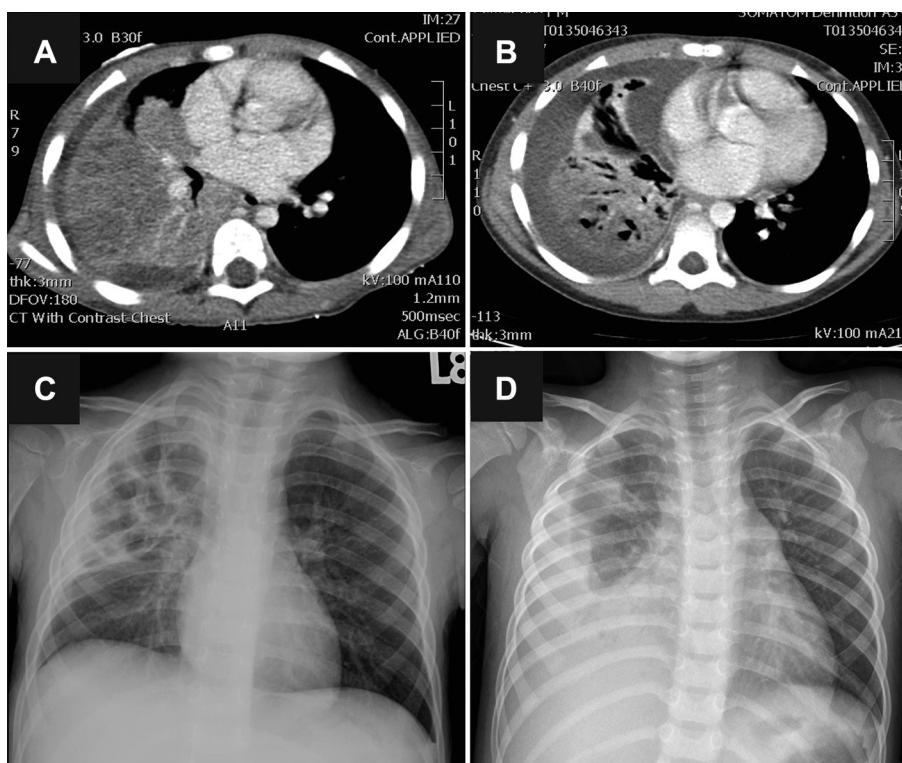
Chest radiographs and computed tomography scans of Patient 1 (A,C) and Patient 2 (B,D).
